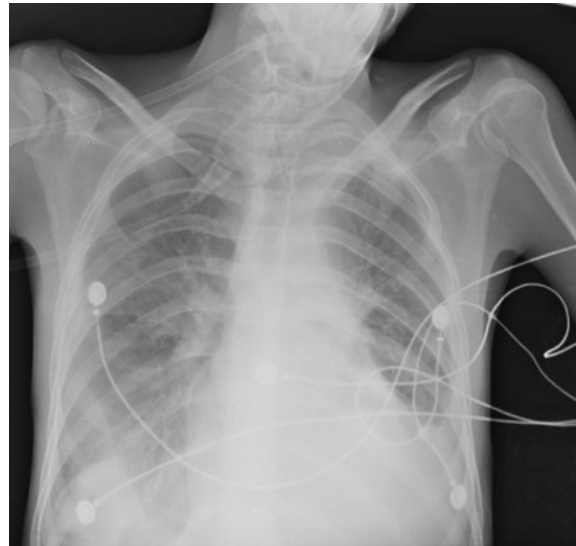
Posteroanterior chest radiograph following removal of the chest tube on hospital day 25.
